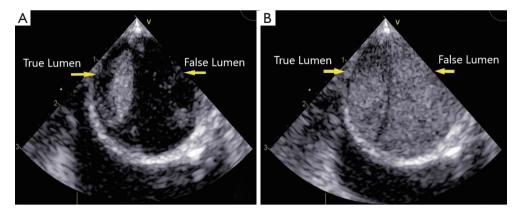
The short axis view of the dissected descending aorta was studied by contrast enhanced transesophageal echocardiography. Upon contrast injection through the extracorporeal membrane oxygenation arterial catheter, the compressed true lumen was enhanced first (A) followed by the false lumen (B).
